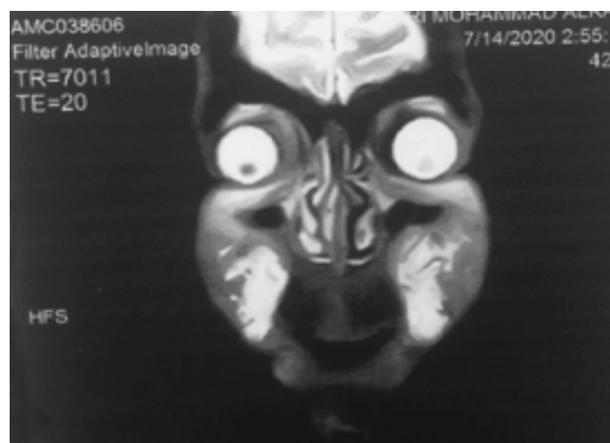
Pre-operative MRI showing the injected facial filler.
